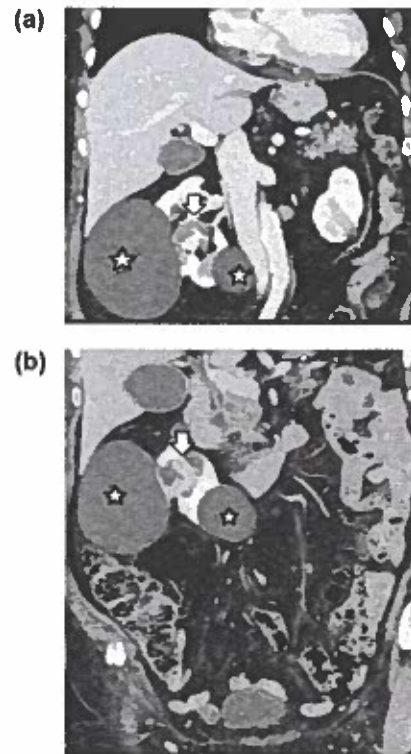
Bosniak classification, version 2019 class III renal cystic mass. Coronal multiplanar reformations during the (a) corticomedullary and the (b) nephrographic phase show a right-sided renal cystic mass (arrow) in the interpolar region, with thick (≥ 4 mm), contrast-enhancing septa. Two other right renal cysts (stars) are also detected as well-defined, homogeneous lesions, with a water CT density and a smooth, thin, barely enhancing wall (Bosniak classification, version 2019 class I, renal cystic mass).
